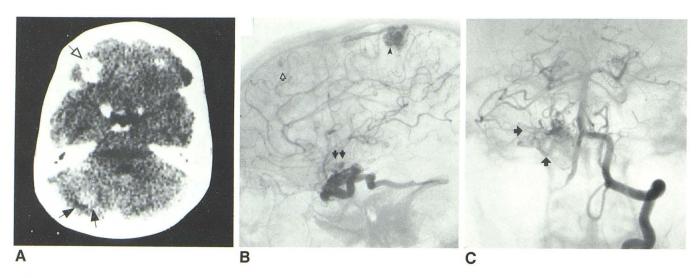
Case 1. A, Axial CT contrast scan demonstrates enhancing high-density foci in right frontal lobe (open arrow) and right cerebellar hemisphere (closed arrows) representing vascular lesions. B, Right internal carotid arteriogram reveals frontal cavernous angioma (open arrow), parietal AVM (arrowhead) draining into superior sagittal sinus, and temporal AVM (closed arrows)
